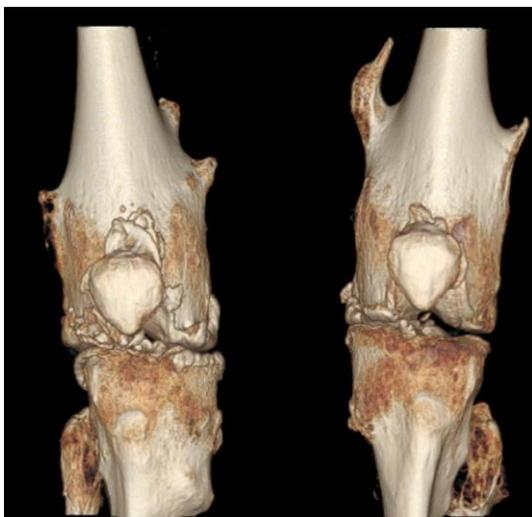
3D reconstruction CT scan of both knees. Intense affection of the articular surface.
